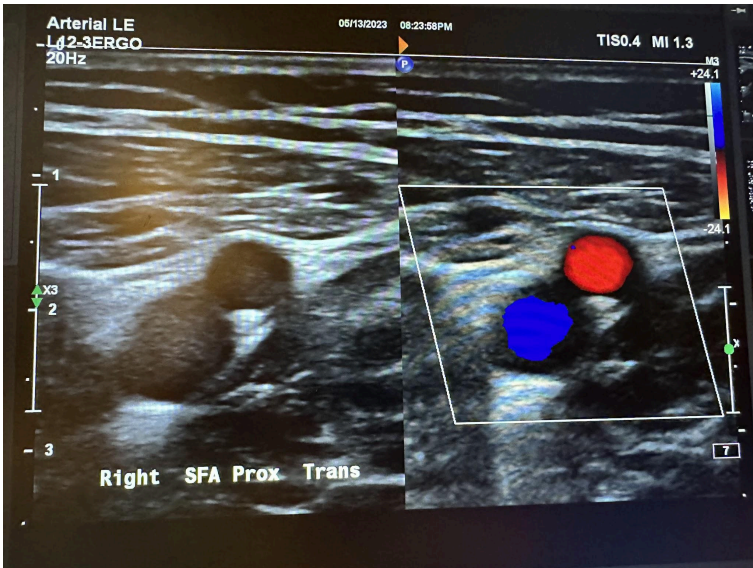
Side-by-side transverse images of the right proximal superficial femoral artery without color Doppler and with color Doppler.
